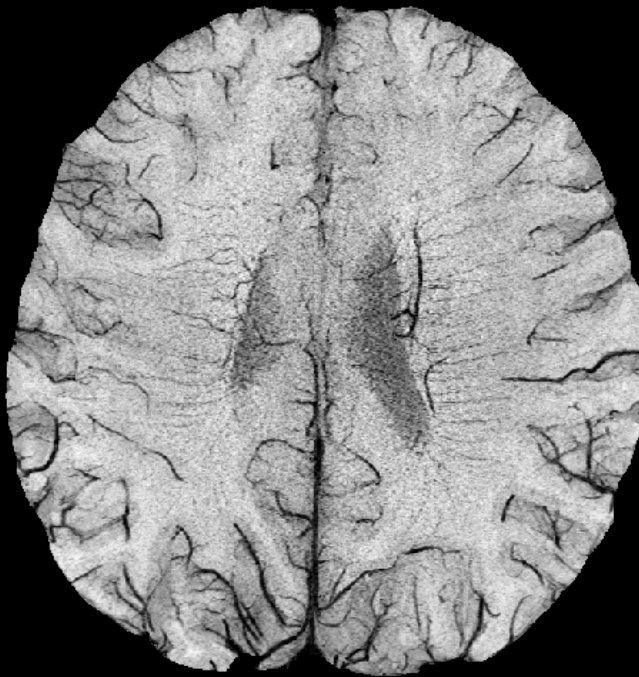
Figure is from Chapter 28, Sedlacik J et. al., in Susceptibility Weighted Imaging in MRI. John Wiley 2011
